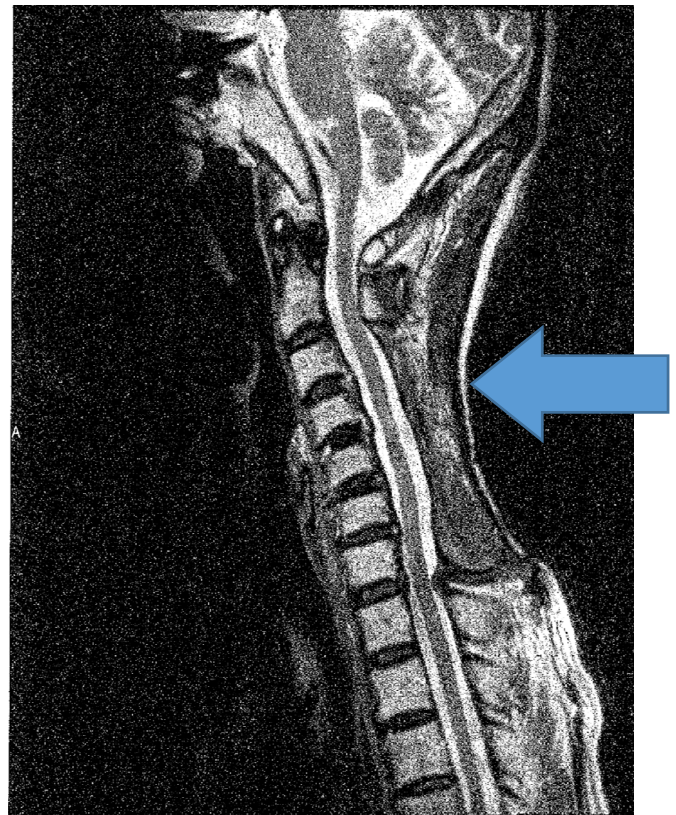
Case 3, CT image after first surgery:
